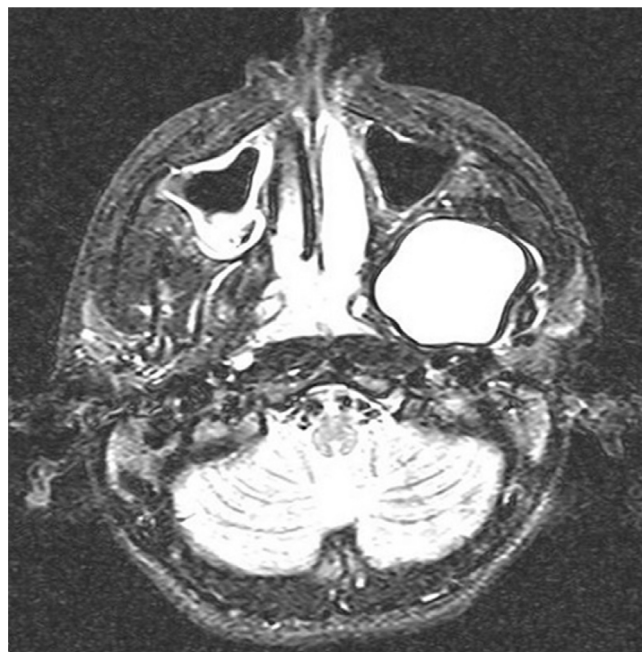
T2-weighted axial MRI. The hyperintense cystic lesion in left pterygopalatine fossa.
